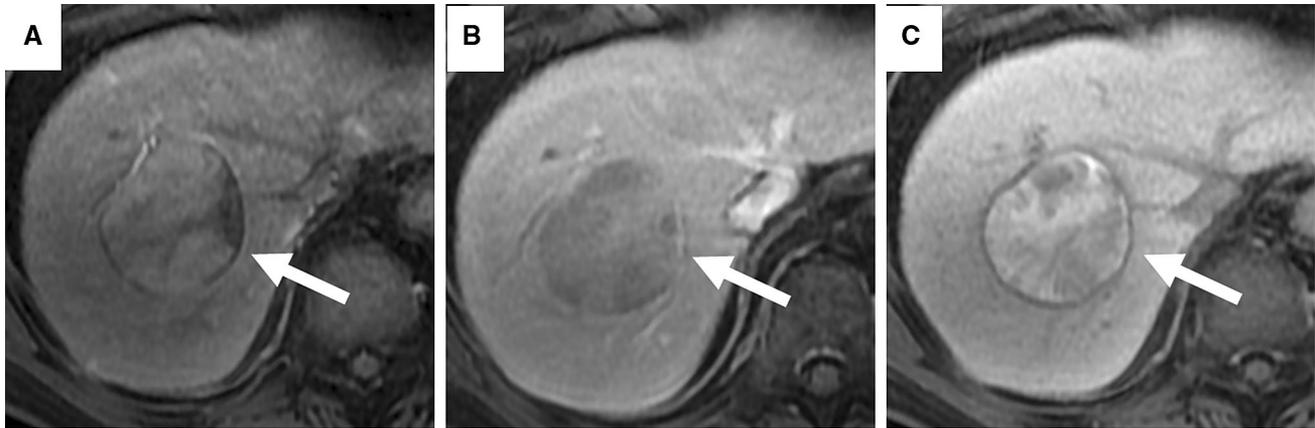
Contrast-enhanced MRI with gadoteric acid (Primovist) in a patient with Child's A liver cirrhosis. Mass (arrows) with characteristic enhancement features of HCC in the arterial (A) and portal venous phases (B). Hepatobiliary phase uptake (C) is atypical for HCC. Nevertheless, arterial phase enhancement and portal venous washout appearance
